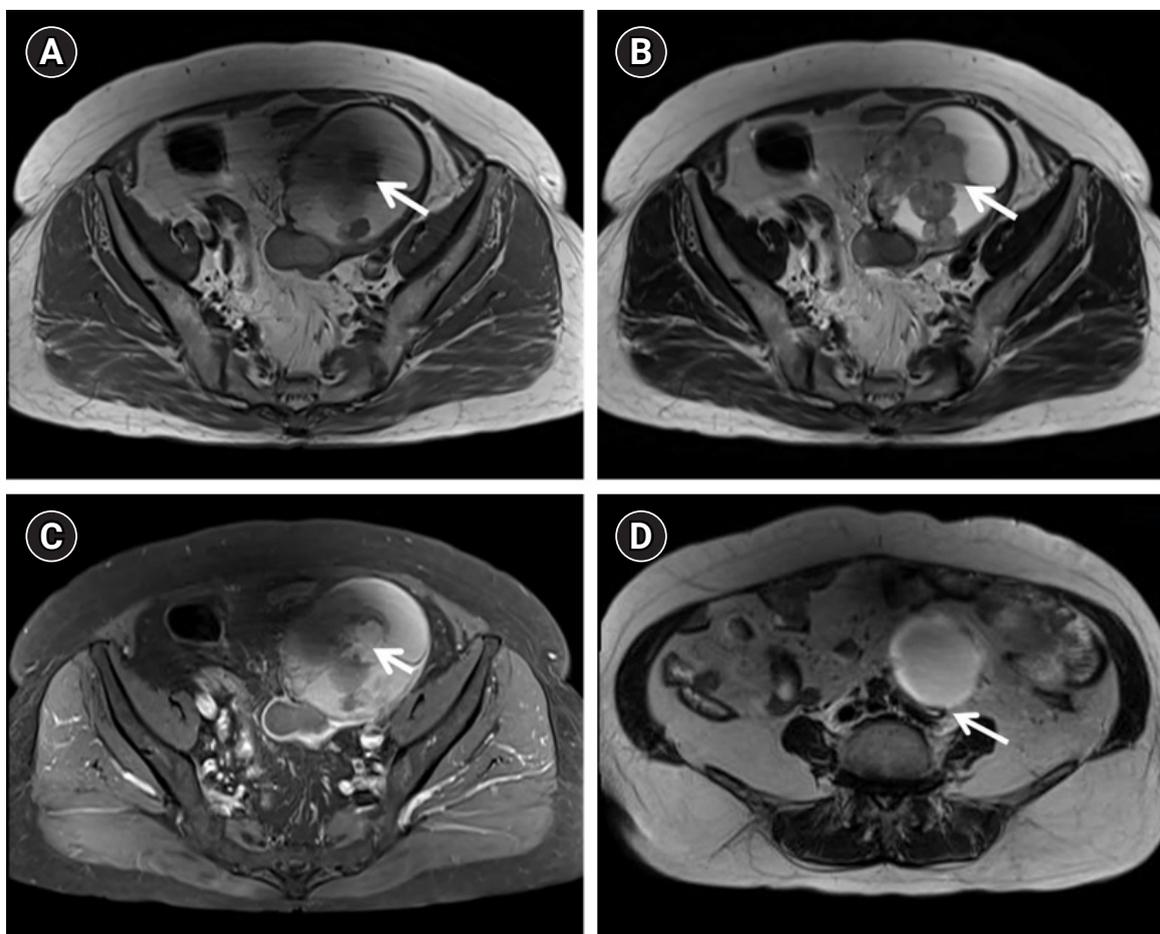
Magnetic resonance images. Axial T1-weighted (A) and T2-weighted (B) images showing a septated hemorrhagic cystic mass with papillary projections (arrow) of the left ovary (ORADS 5). High T1 signal intensity with the T2 dark spot sign, suggestive of epithelial ovarian cancer associated with endometrioma (e.g., clear cell carcinoma or endometrioid carcinoma). (C) Contrast-enhanced axial T1-weighted image shows enhancement (arrow) of the papillary projections in the left ovarian tumor. (D) Axial T2-weighted imaging revealed left hydronephrosis (arrow), showing abrupt narrowing at the ovarian mass level suggestive of ureteral invasion. ORADS, Ovarian-Adnexal Reporting & Data System.
